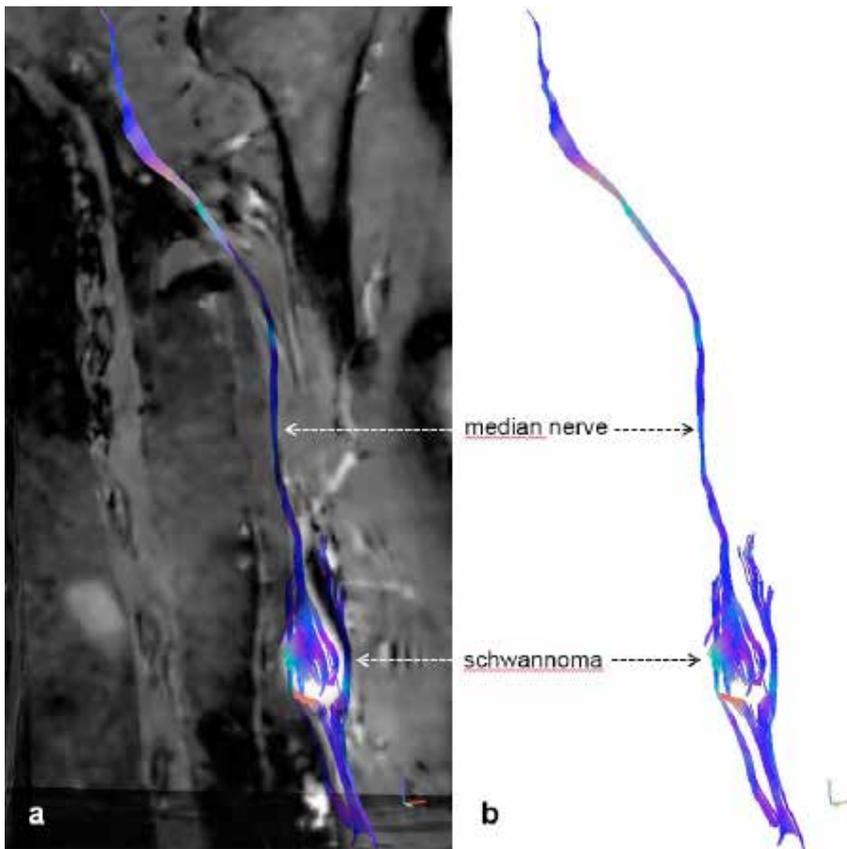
3D MR tractography (MRT) of schwannoma of the median nerve – (a) neural fascicle projection into basic structural images of conventional MRI and (b) isolated MRT reconstruction
